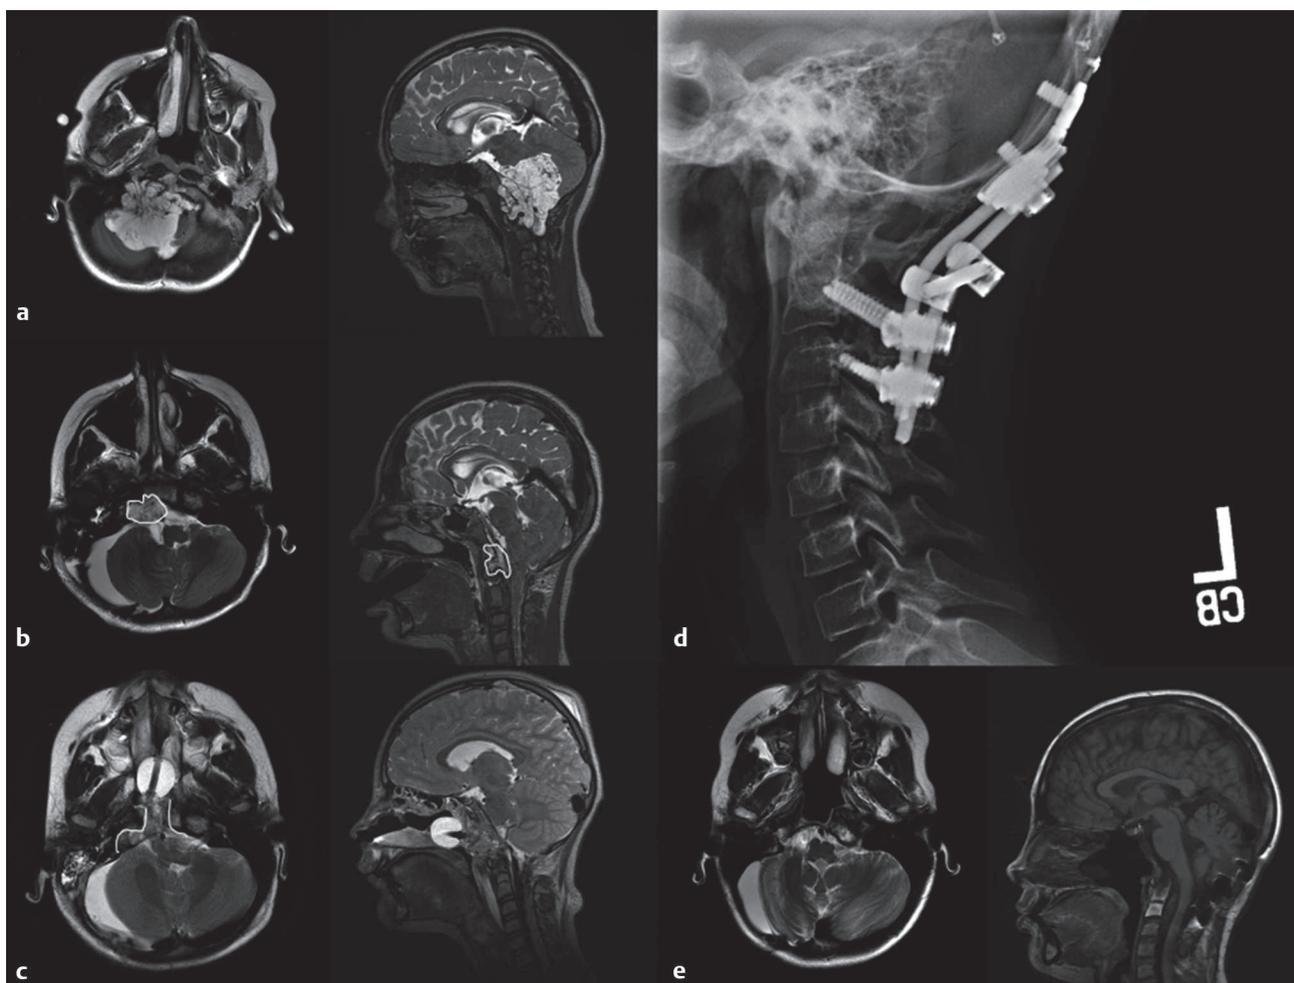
(a) Preoperative axial and sagittal T2-weighted images of a large chordoma. (b) Axial and sagittal T2-weighted images after a far lateral approach. Areas of residual tumor are outlined in white. (c) Axial and sagittal T2-weighted images after an endoscopic endonasal approach for residual tumor involving the clivus and C1–2 joint space. The surgical corridor is outlined in white on the axial image. (d) Occipital cervical fusion was performed after complete resection of the right condyle via far lateral and endoscopic endonasal approaches. (e) Axial T2-weighted image and sagittal FLAIR (fluid-attenuated inversion recovery) image 2 years after resection and proton beam therapy. Radiation changes can be seen in the dens.
